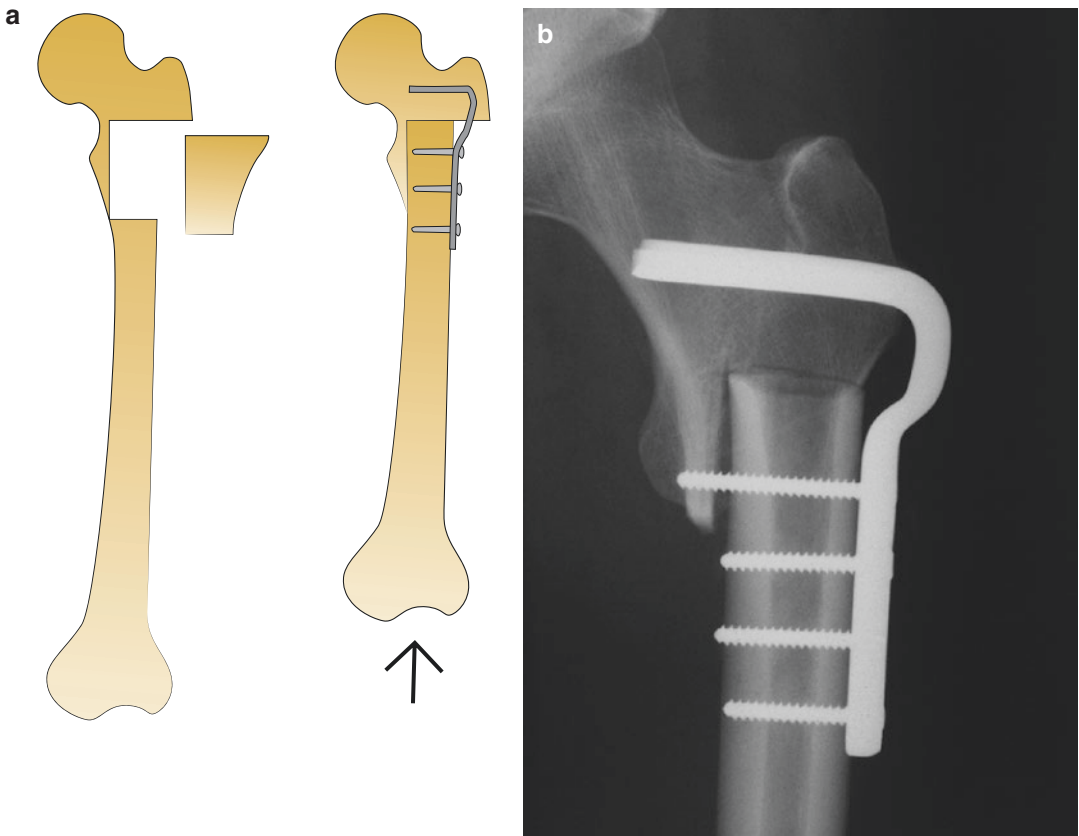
(a) Shortening of the upper leg can be carried out by removing a piece of bone just under the hip joints with fixation of the bone using a hook plate and screws. (b) Postoperative X-ray
